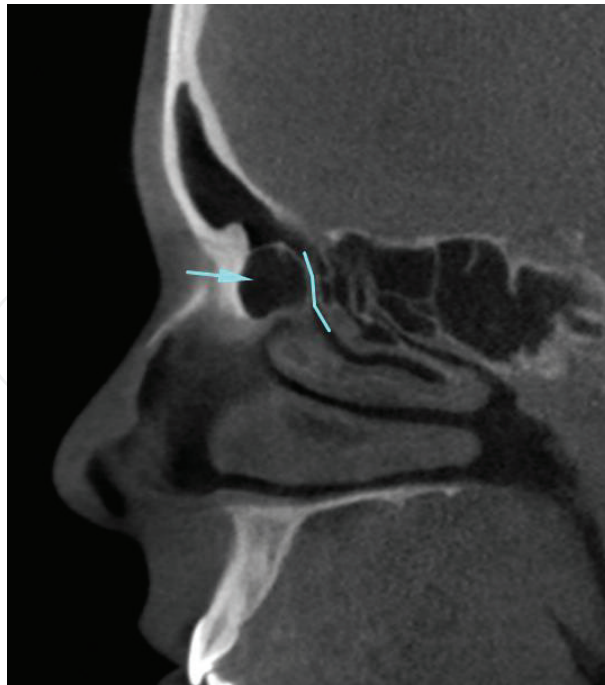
Sagittal CBCT images showing the large ANC (arrow) and its relation with the FR (line).
